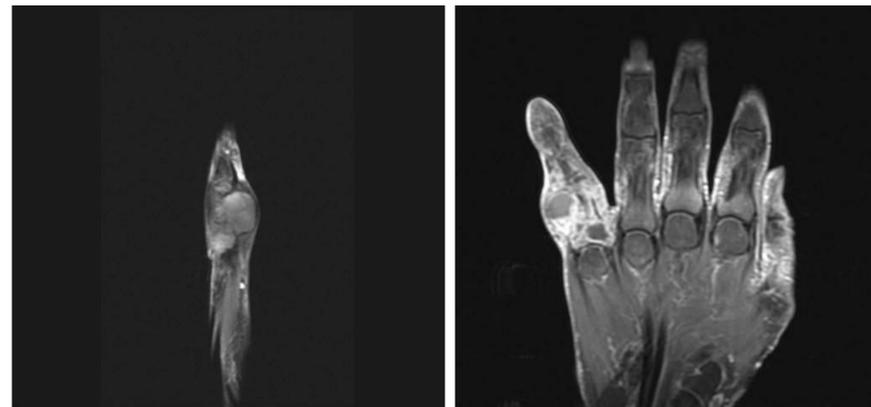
MRI of the right hand, sagittal fat sat pre-contrast (left) and coronal T1 fat sat post-contrast (right) showing associated soft tissue mass.
